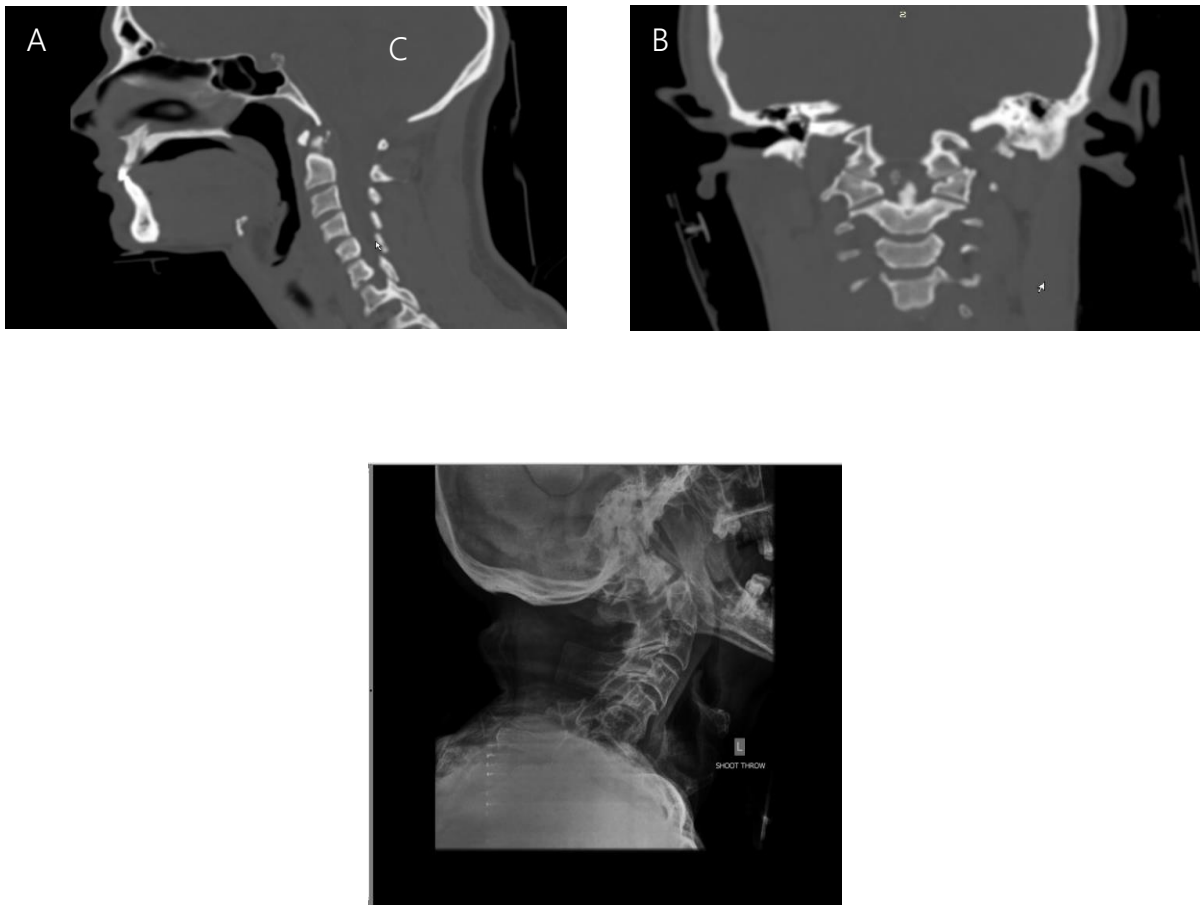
This lateral view plane cervical X-ray image depicts the cervical spine.
